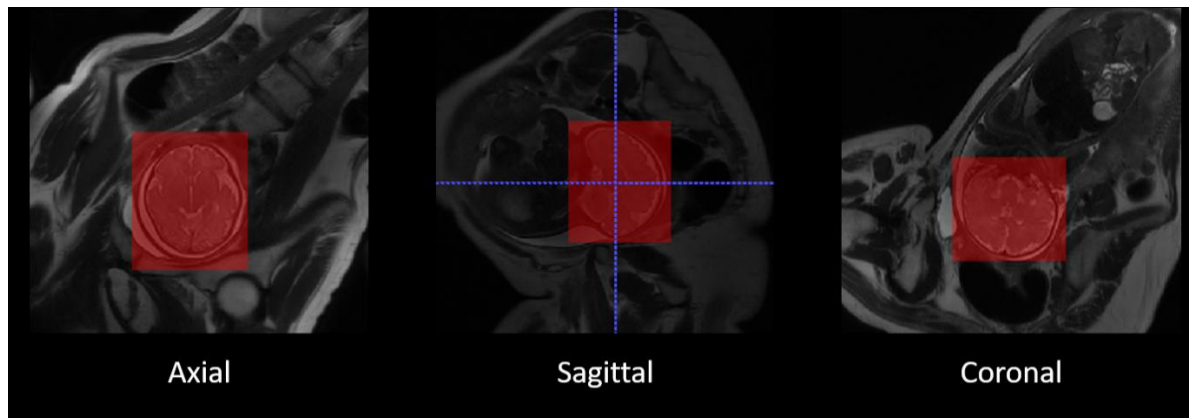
The red boxes represent the broad localization of the fetal brain in the three different image planes. T2-weighted images acquired separately in three separate image planes in the axial (left), sagittal (middle) and coronal (left) in a representative participant with broad localization of the fetal brain (red boxes).
